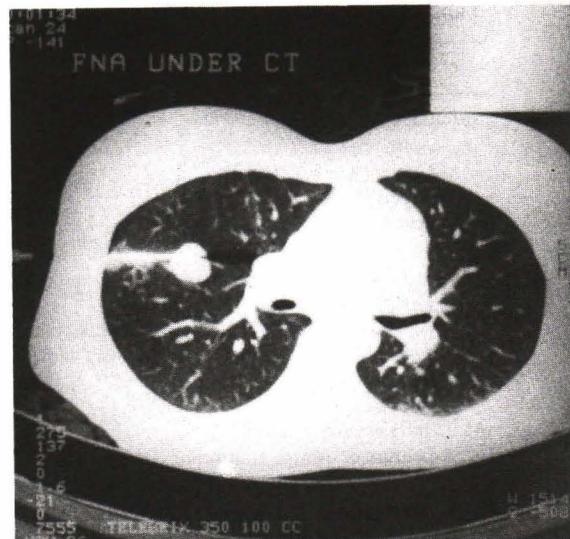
CT-guided percutaneous transthoracic needle aspiration of the intrapulmonary nodule in one case.
